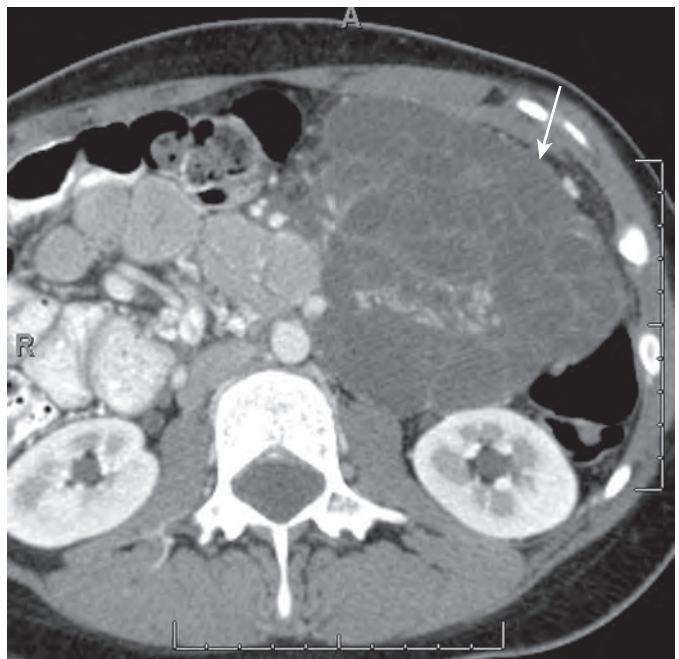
Mesenteric lymphangioma. Axial CT demonstrating a multicystic mass consistent with a mesenteric lymphangioma (arrow).
